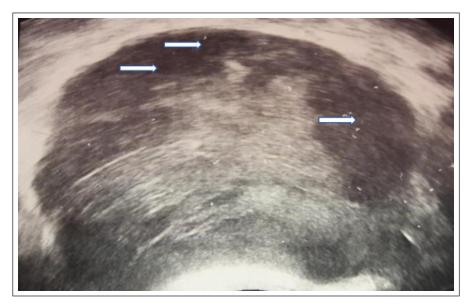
Ultrasound of the prostate showing the presence of an abscess (arrows).
